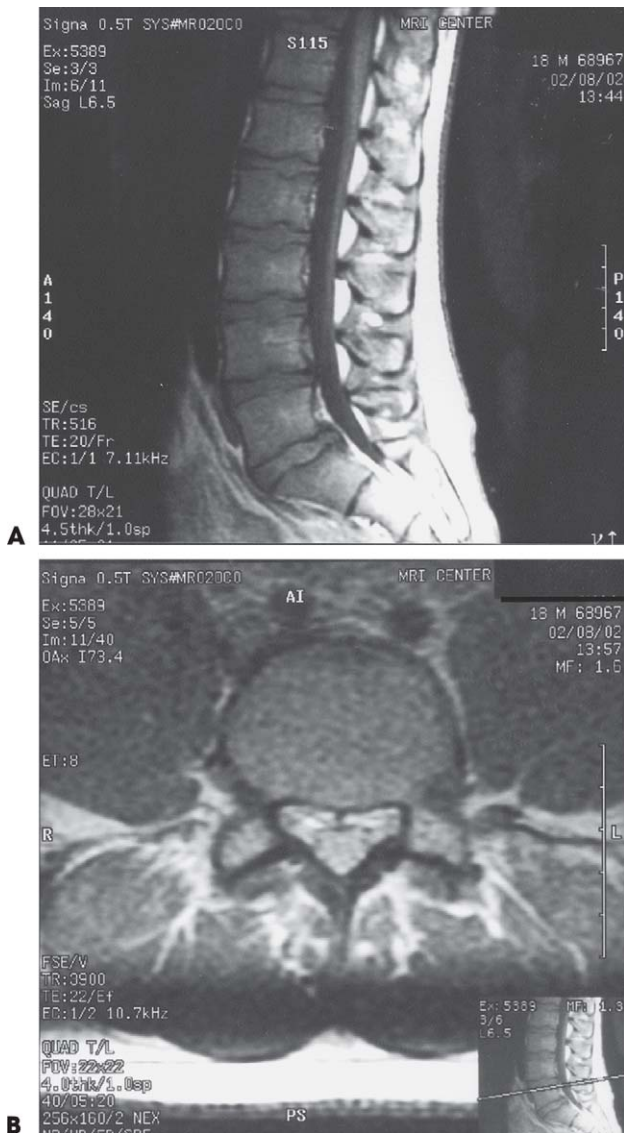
A and B. Sagittal T1-weighted MRI of lumbar spine (A) shows spondylolisthesis of L5/S1 and a widened AP diameter of the vertebral canal. Axial proton density-weighted MRI of lumbar spine (B) reveals bilateral linear low signal intensity through the pars interarticularis bilaterally, indicative of chronic pars defects.
